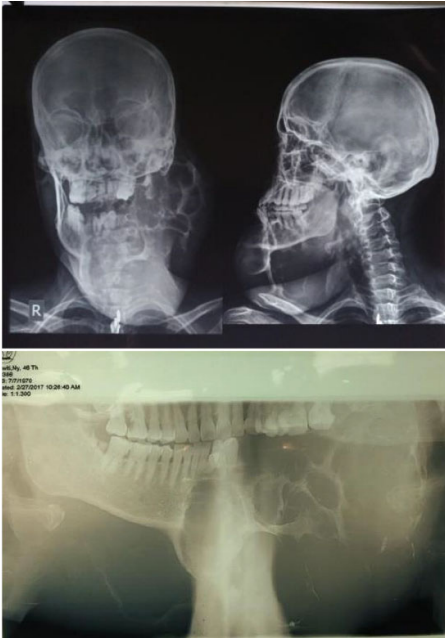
The X-ray head AP/Lateral (left) x-ray photograph panoramic (right)
